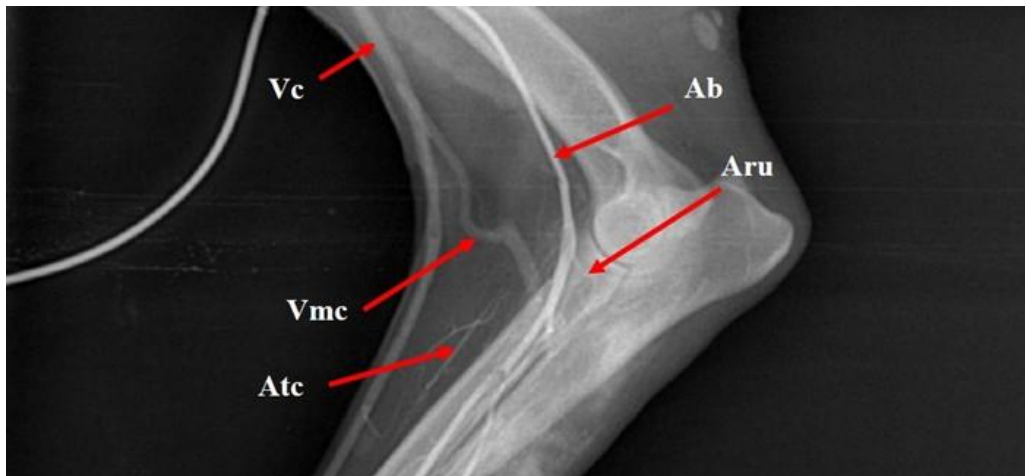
In vivo radiography in medio-lateral view - Ab – a. brachialis, Aru – a. recurrens ulnaris, Atc – a. transversa cubiti, Vc – v. cephalica, Vmc – v. mediana cubiti.
